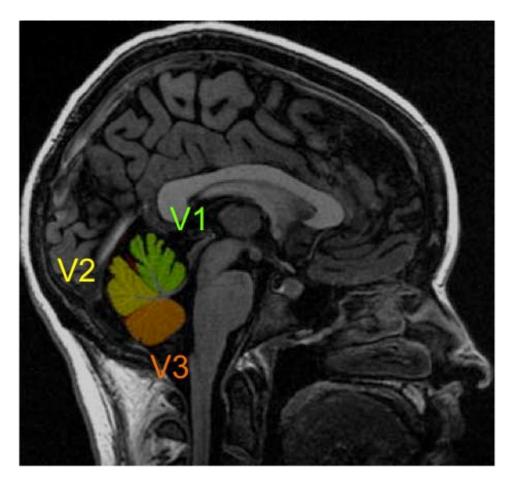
The cerebellar vermis on a typical mid-sagittal MR image
